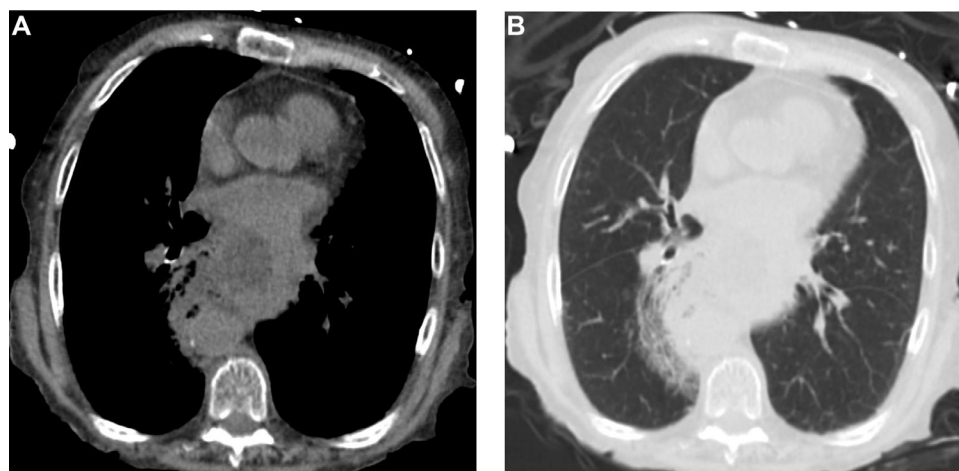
Axial noncontrast CT images in mediastinal (A) and lung (B) windows showing early esophageal rupture (arrows) with adjacent right lower lobe consolidation (arrowheads).
